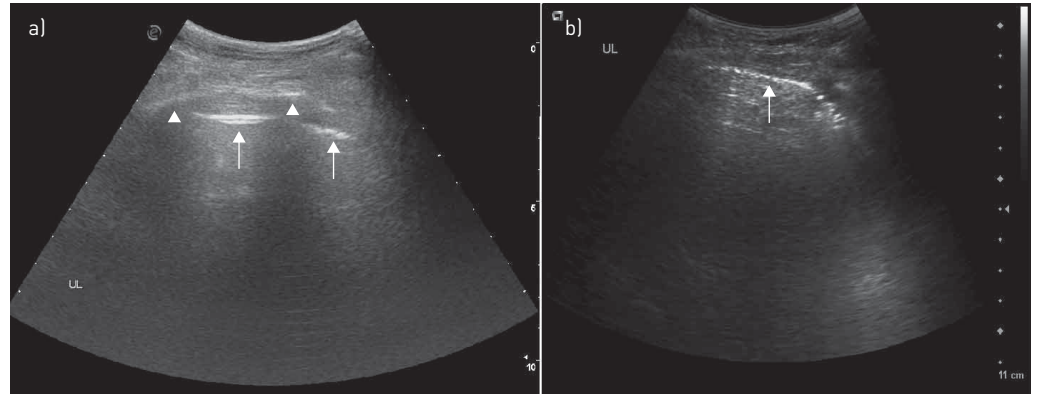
a) Thoracic ultrasound using low frequency probe oriented perpendicular to the intercostal space long axis. Note how the ribs (arrowheads) cast deep shadows causing interruption to the pleural line (arrows). b) The same image after orienting the probe to remove the rib shadows. Note the continuous pleural line (arrow).
